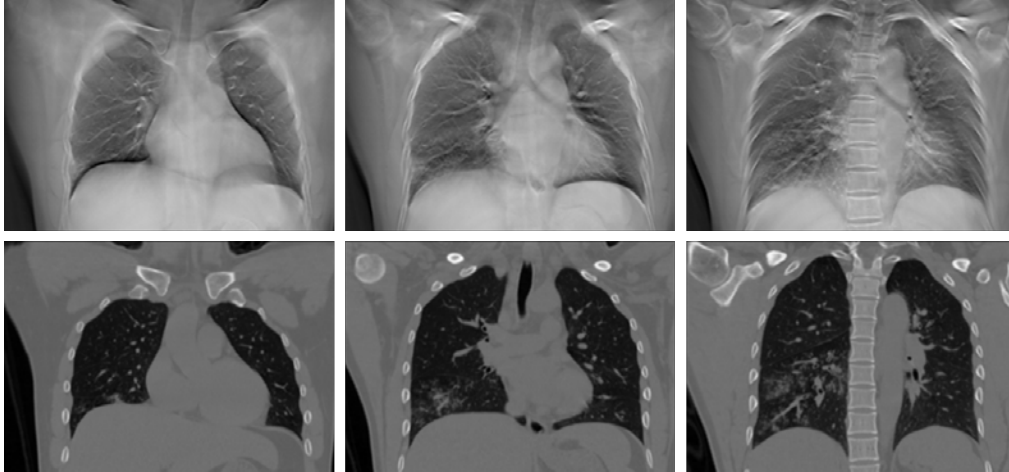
Coronal slices of the result of FDK-based reconstruction from the tomosynthesis data (top) and their corresponding CT (bottom).
